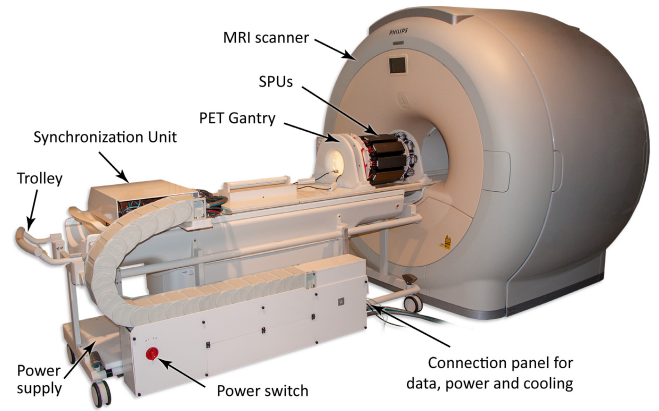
Gantry of the PET insert holds ten SPUs. The gantry is mounted on a trolley, which allows easy insertion into the clinical MRI scanner. A synchronization unit and a power supply are also mounted onto the trolley. Only a single data cable, a power cable, and the cooling tubes have to be connected, which allows for an easy installation and mobile setup (adapted and reprinted from [1] ©3.0).
